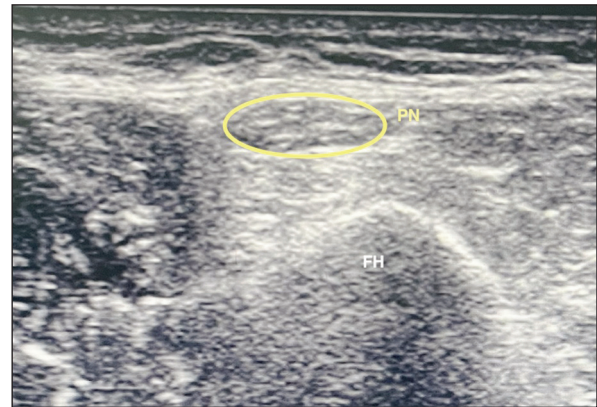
Peroneal nerve on the fibular head with ultrasound.
